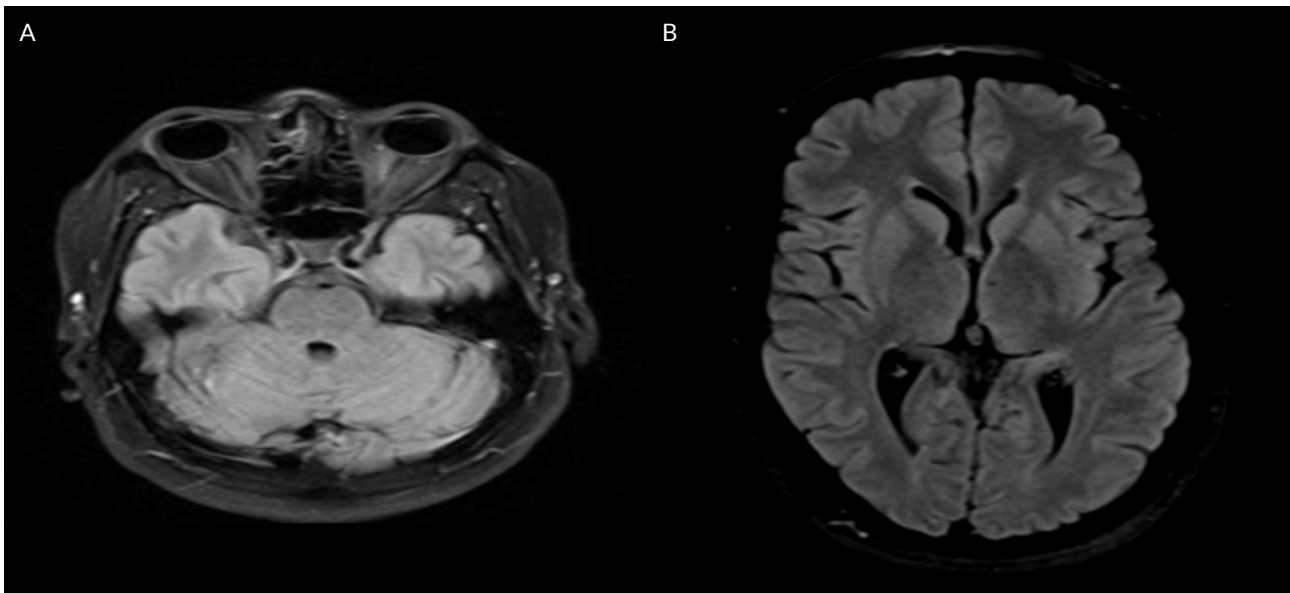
Brain magnetic resonance imaging at the 2-month follow-up after treatment. A) It was observed that the lesion detected at the level of the pons had disappeared; B) The disappearance of the lesions observed in the left internal capsule and left parietal region of the basal ganglia was observed.
